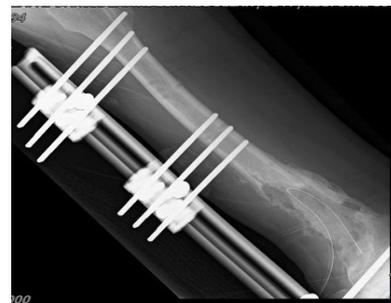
Right femur radiograph post LRS fixation
